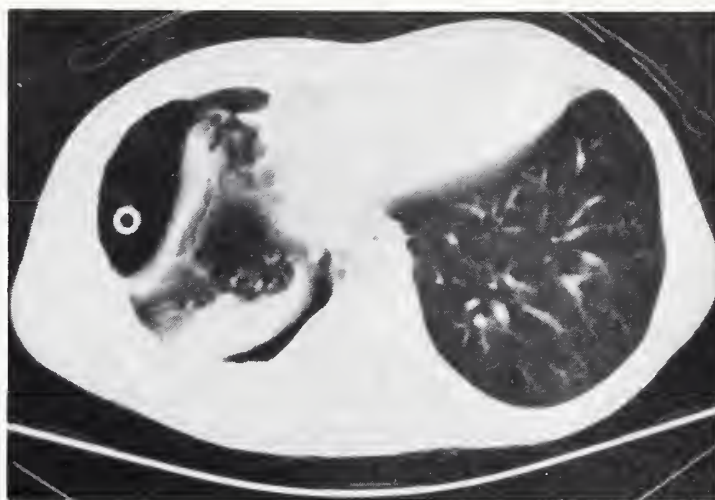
Chest radiograph: Chest tube drainage of tuberculous empyema.
